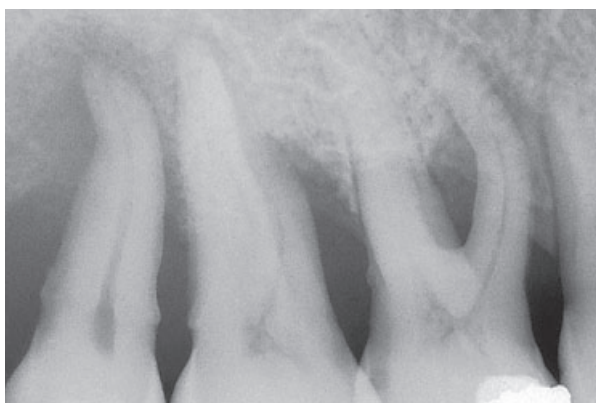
Radiograph indicating the presence of a degree III involvement of the buccal furcation of the maxillary first molar. This tooth is a candidate for root resection.
